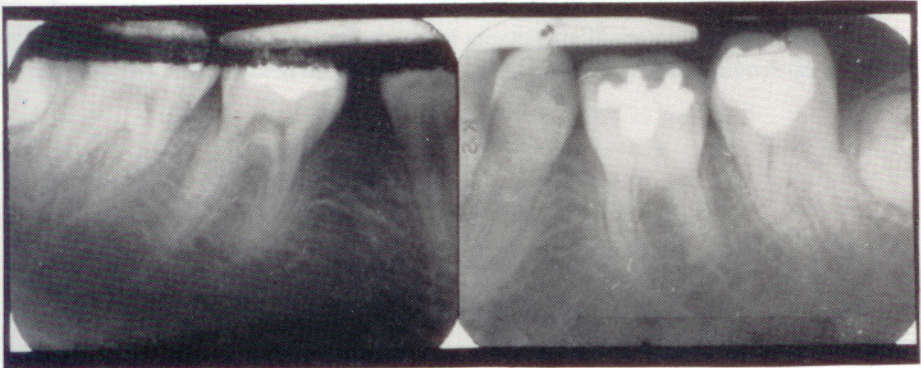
Ante-mortem periapical radiographs of patient G.C. Note that the mandibular 2nd premolar (35 and 45) are absent.
